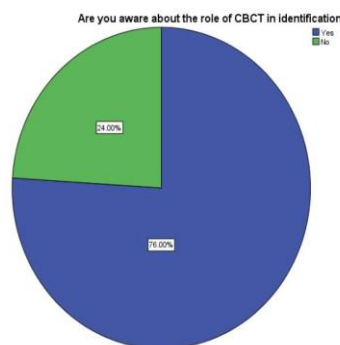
Pie chart shows the percentage of awareness of the role of identification in CBCT, in that 76% of the participants were aware about the CBCT and 24 % were not aware about the CBCT, blue indicated the participant who were aware and green indicated participants who were not aware.
